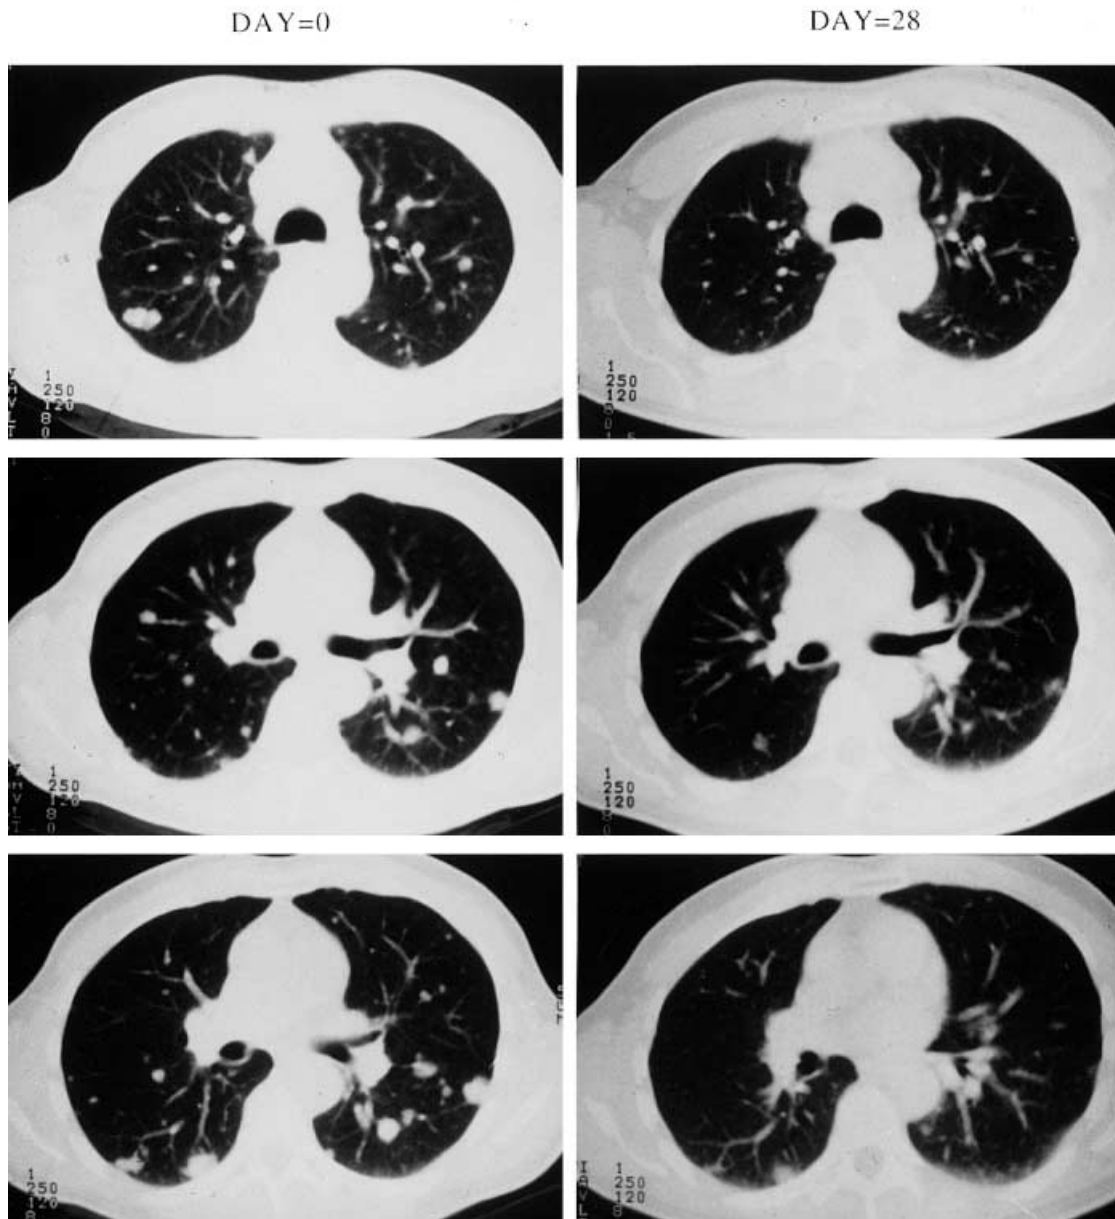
Computed tomography imaging of pulmonary metastases in a patient with RCC treated with *MFG-GM-CSF*-transduced RCC vaccine injections reveals a partial response as a consequence of treatment
